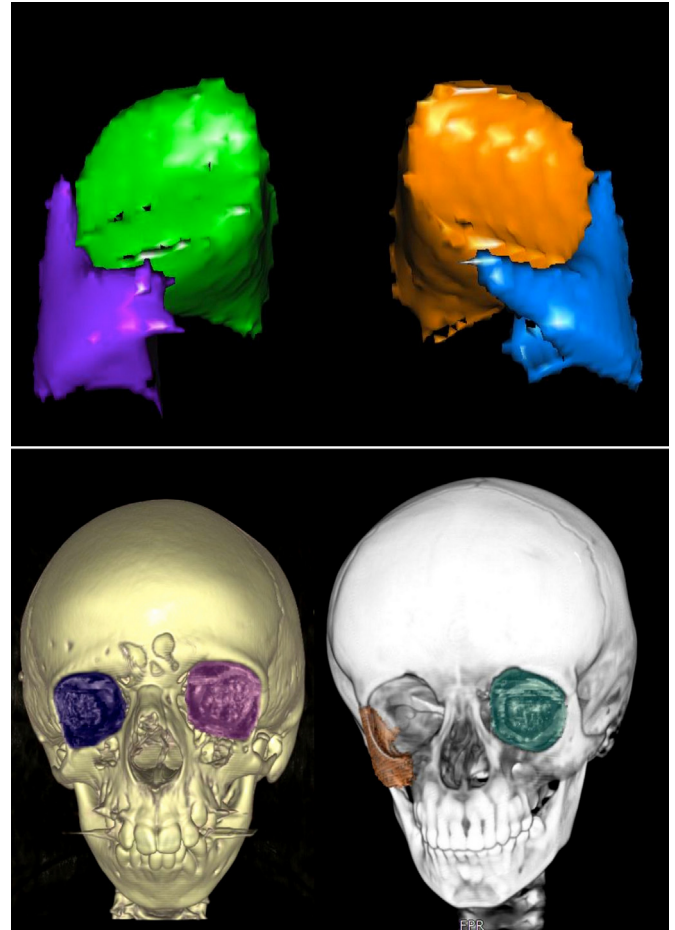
Volumetric representation of the studied volumes on CT in TCS patients and control patients. Orbits and zygomatic bones.
